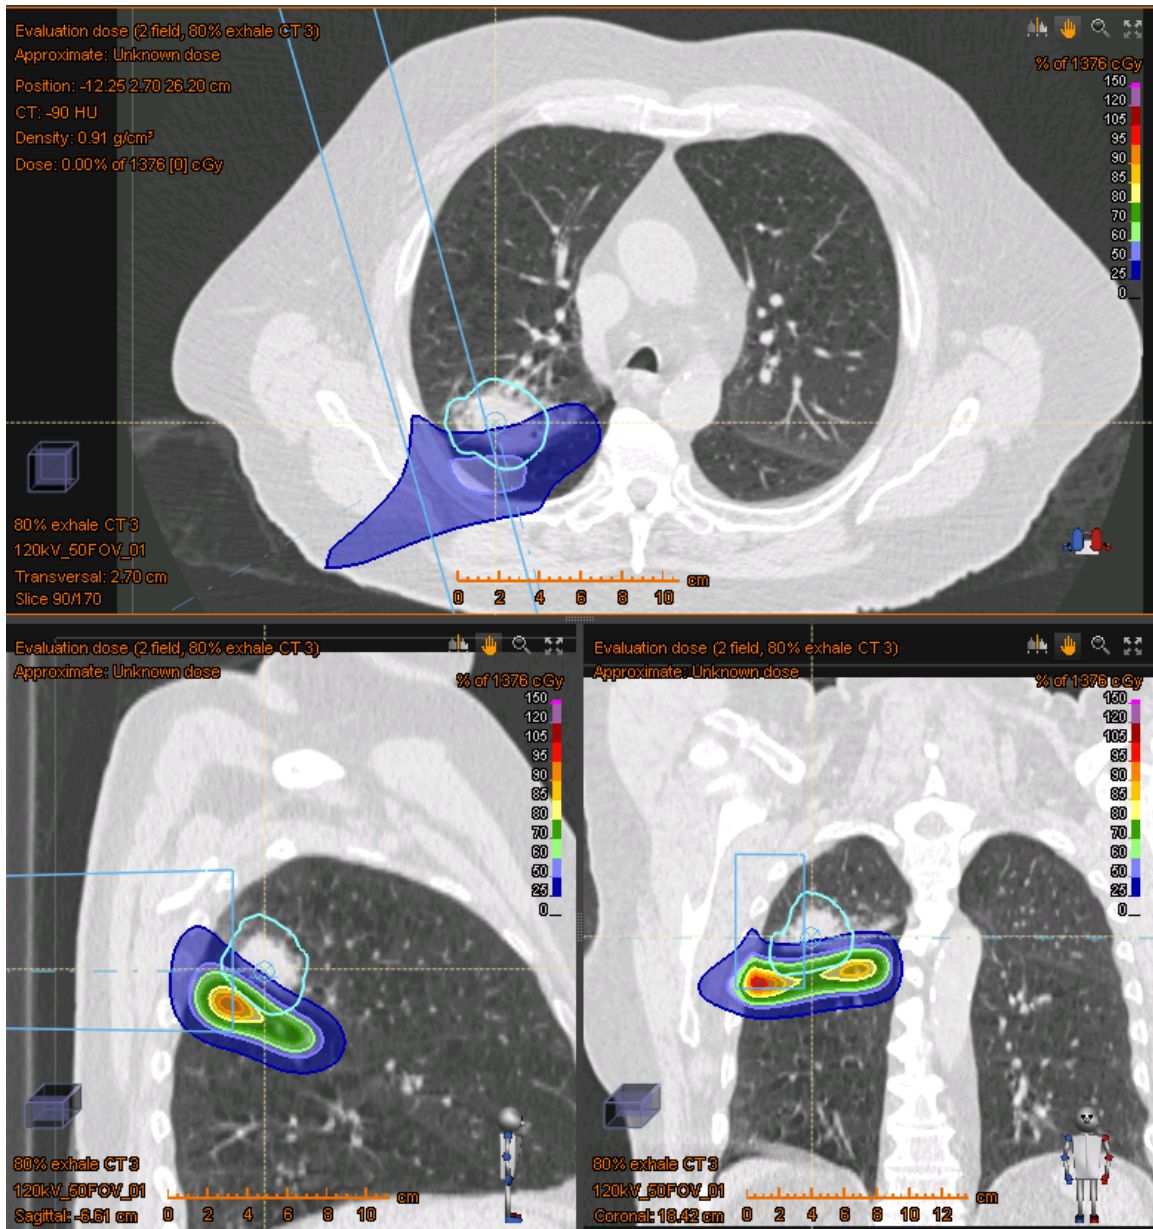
Field 1&2 – Dose delivered to 80% exhale CT phase
